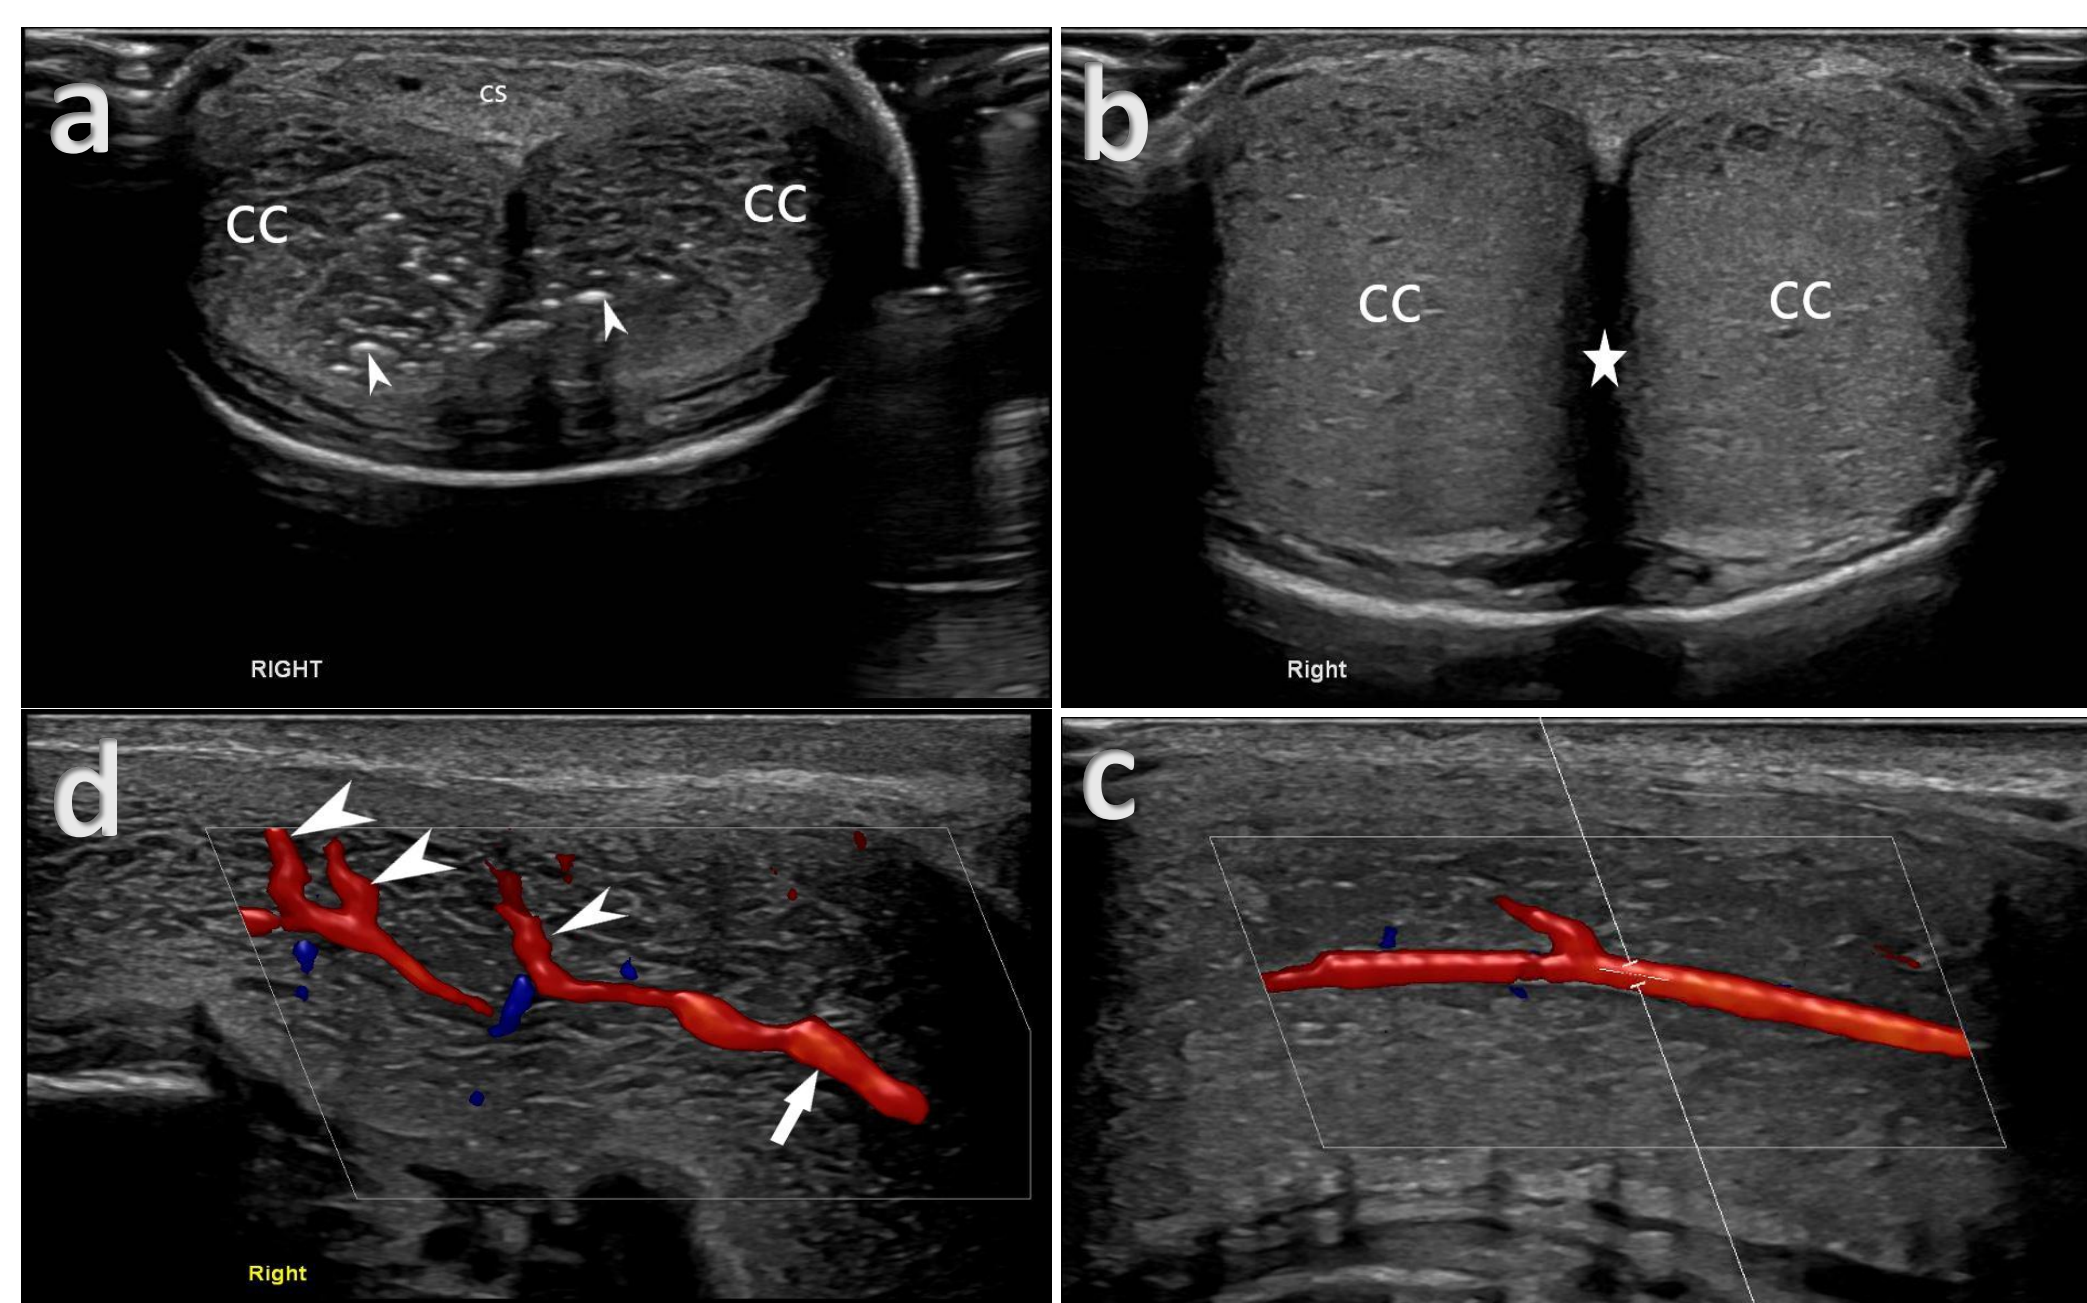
Penile ultrasound anatomy post Caverject injection. (a) Normal penile ultrasound anatomy showing the echogenic flecks of the Caverject bubbles (2 arrow heads) travelling within the sinusoids of the CC with some secondary sinusoidal. (b) B-mode ultrasound of the erect penis in axial orientation, note the shadowing from the penile septum (star). (c) CDI of the cavernosal artery and (d) CDI showing the cavernosal artery (arrow) and the helicine arterioles (3 arrow heads)
